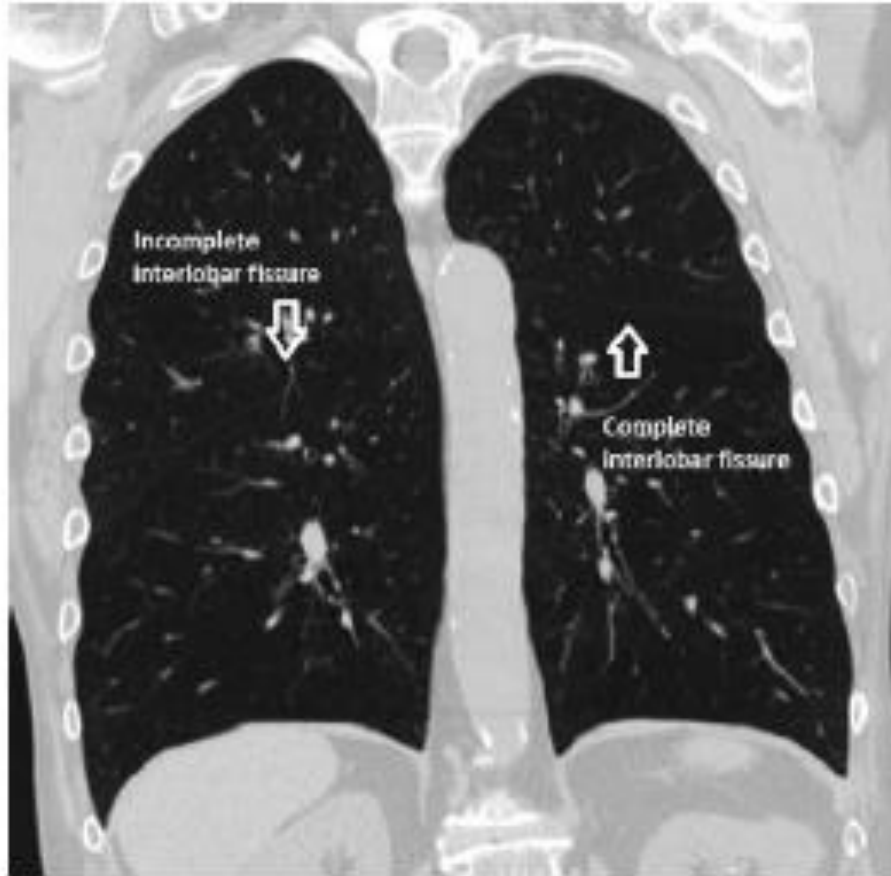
Computed tomography showing an incomplete major fissure on the right and a complete interlobar fissure on the left.
